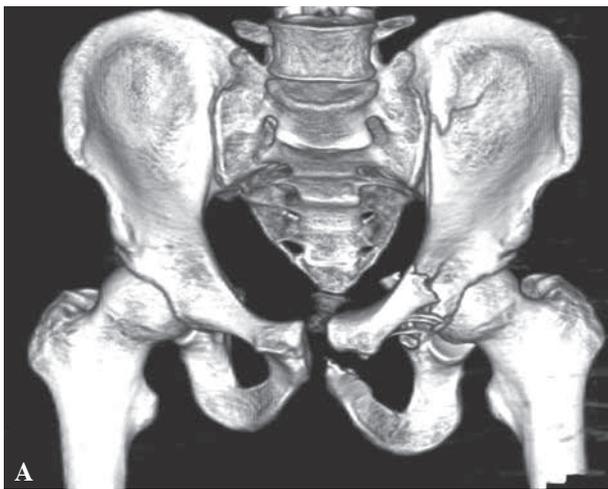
Radiological results of a 28-year-old male patient after polytrauma including pelvic fractures: A. computed tomography of the pelvis showing an unstable pelvic injury including left-sided fracture of both columns of the acetabulum (type C2), fracture of both pubic rami and iliac bone fractures, and fracture of the sacrum; B. postoperative radiograph (anteroposterior view) with anatomic reduction and internal fixation using a modified Stoppa approach; C. radiograph (anteroposterior view) at 24 months follow-up with healed and remodeled pelvic bones; the Majeed score was 100, an excellent clinical result; D. radiograph (inlet view) at 24 months follow-up; E. radiograph (outlet view) at 24 months follow-up.
